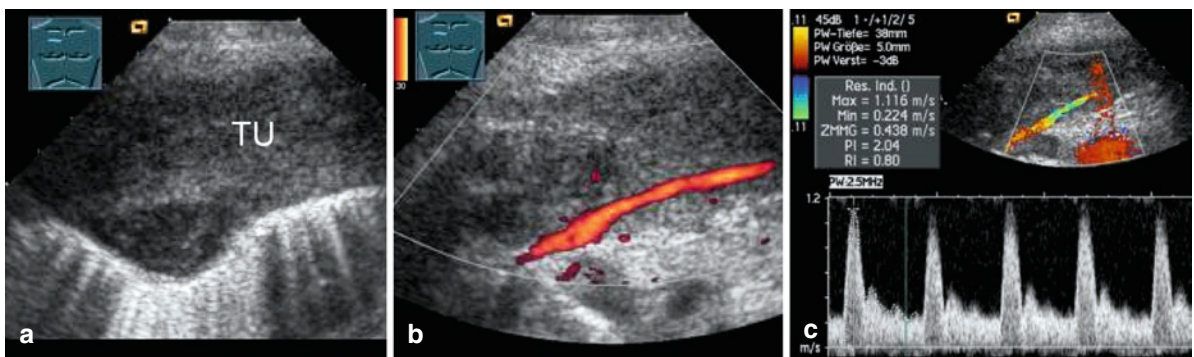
A 45-year-old man with a chest wall metastasis and known hypernephroma. (a) B-mode sonography reveals a large hypoechoic transformation of the chest wall (TU) on the left side.
